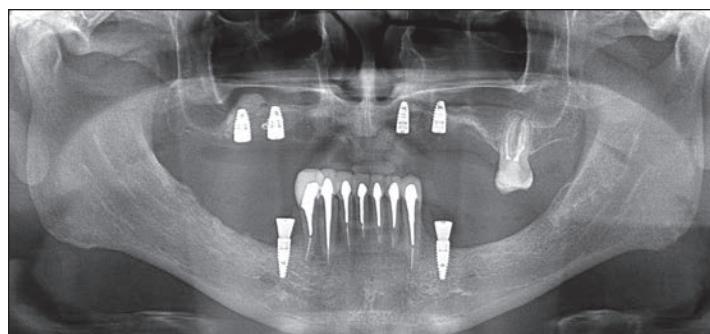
Panoramic radiograph of newly placed implants after sinus elevation and guided bone regeneration.
